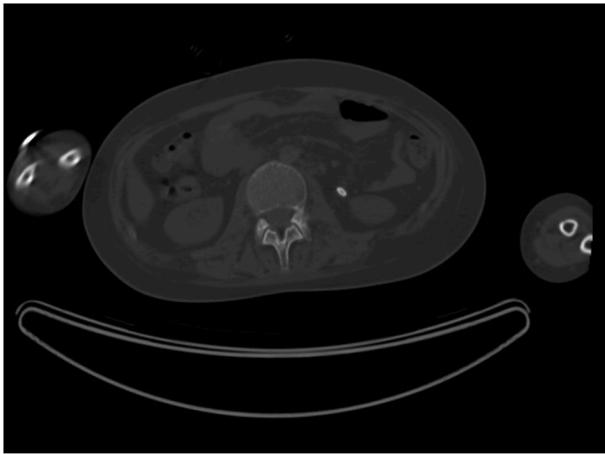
Computed tomography scan showing a 10 mm stone at the level of the left ureteropelvic junction. The image analysis revealed a stone density <1,000 Hounsfield units.
